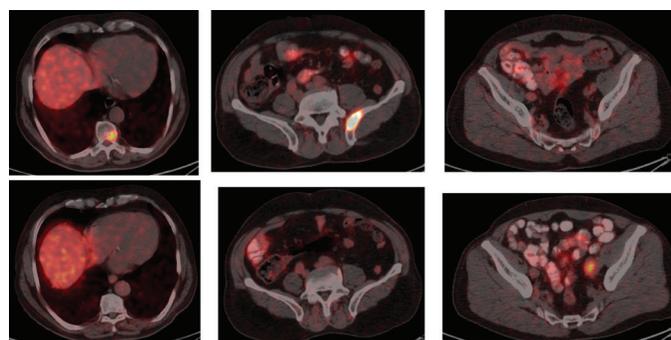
Pathological activity in multiple foci in skeletal system and left obturator lymph nodes in Ga-68 PSMA PET/CT performed in a 77-year-old patient with a prostate needle biopsy result compatible with acinar adenocarcinoma (Gleason 4+5) (First line). It was noted that activity in the bone lesions and lymph nodes defined in the Ga-68 PSMA PET/CT performed for the purpose of evaluating the response to treatment after hormoneotherapy decreased significantly (Second line)
